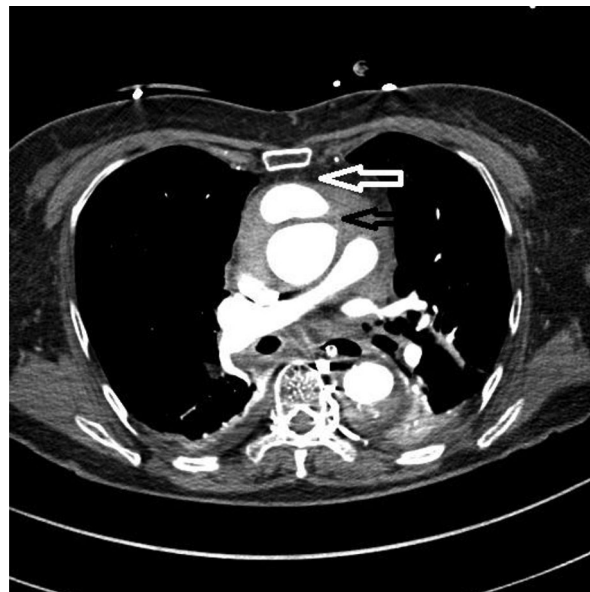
Chest CTA showing false and true lumens of the ascending aorta (white and black arrows, respectively).
